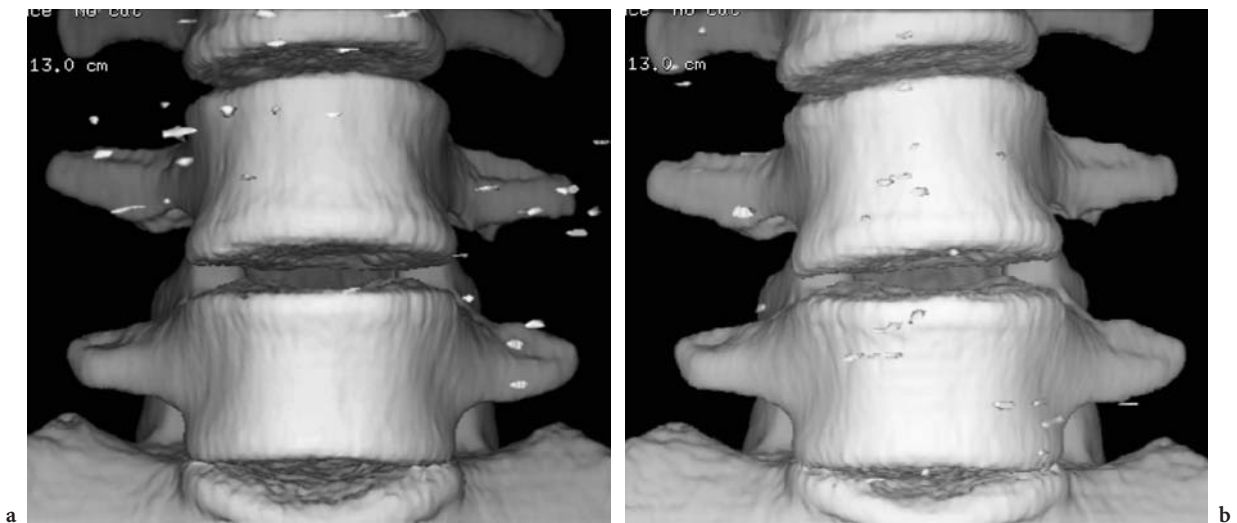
Rotation around the Z-axis during loading (same patient as in Fig. 9.6). a Supine-unloaded CT: the lumbar spine is parallel to the sagittal plane. b During AL-CT: CCW rotation of L4 along the “Z” axis
